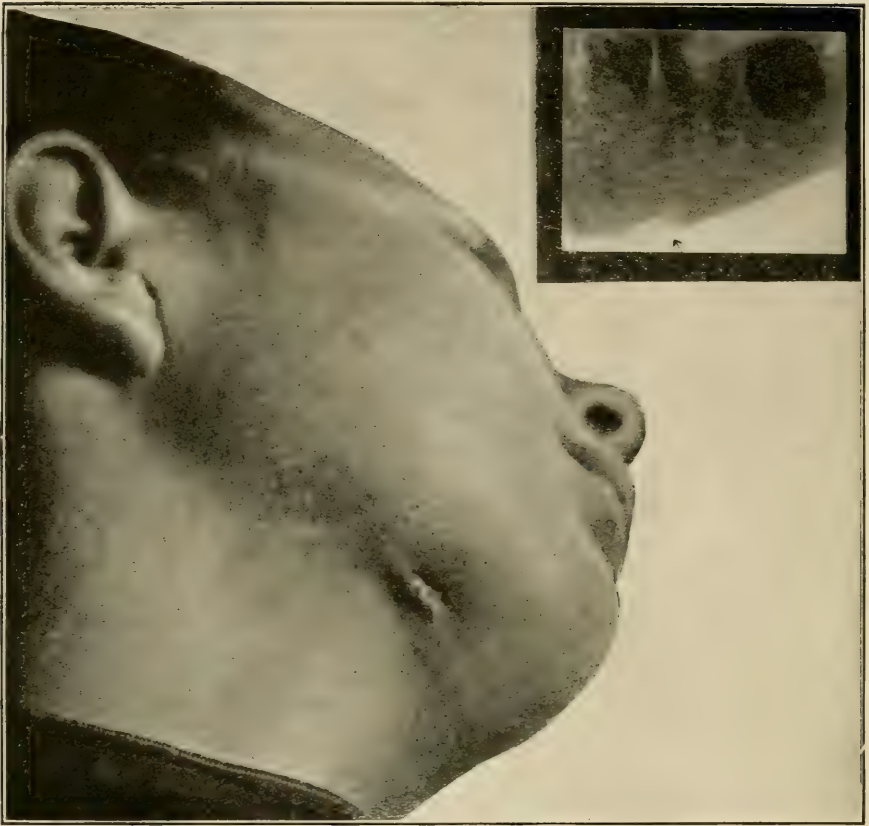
Photograph of a case of so-called Ludwig's angina. Also a radiograph of the case showing an abscess of the first permanent molar. The fistulous tract cannot be seen.
